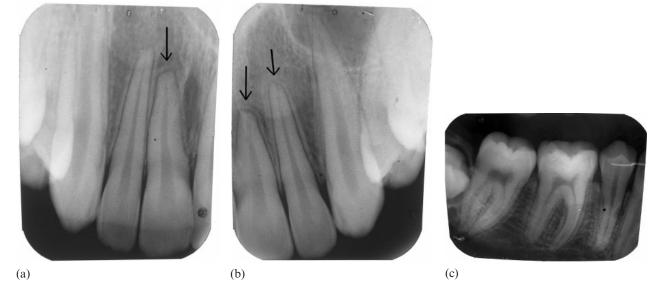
Periapical radiograph of (a,b) maxillary central incisors (black arrows show minor blunting of the apical root tips) and (c) lower right first molar
